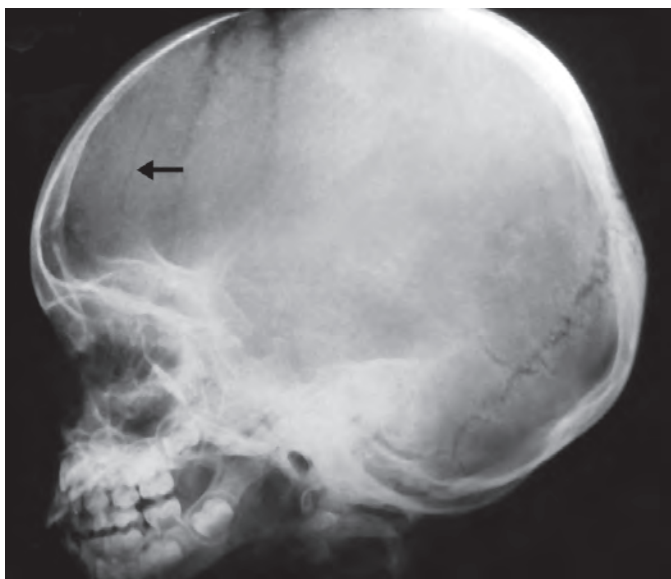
Linear fracture X-ray
